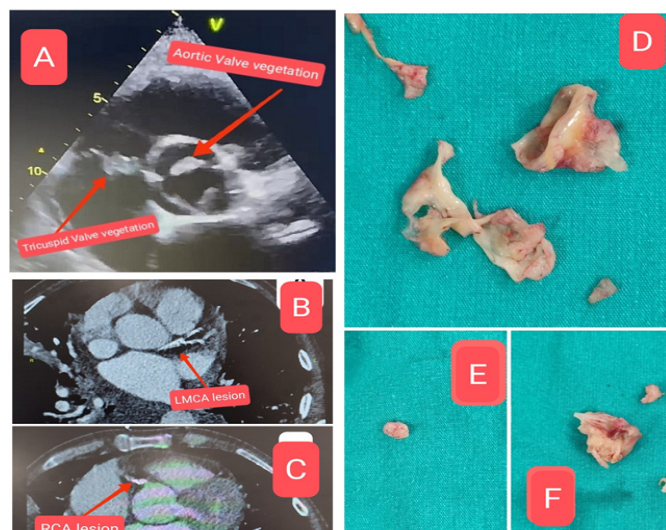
Preoperative echocardiographic and coronary computed tomography angiographic findings, and intraoperative images of the resected aortic, mitral, and tricuspid valves with vegetations.
